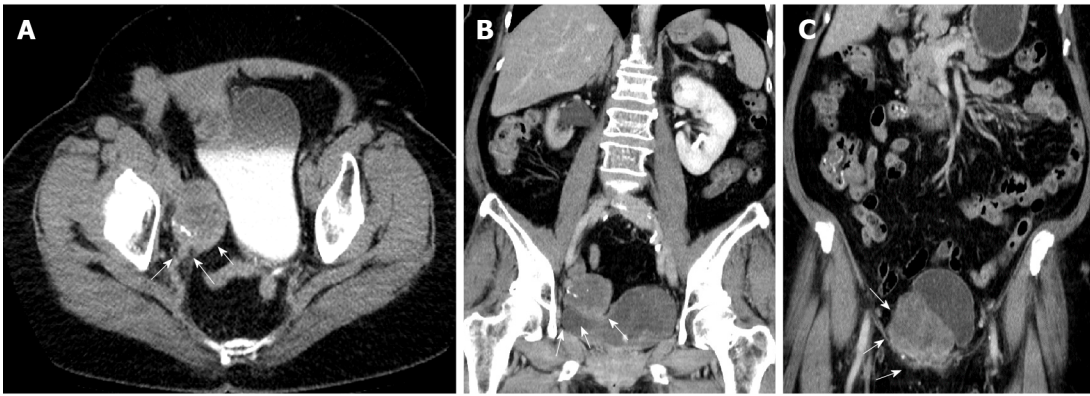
Abdominal computed tomography demonstrated that the tumor extended from the right distal third ureter to the ureterovesical junction. A: White arrowhead in the axial view; B and C: Coronal view.
